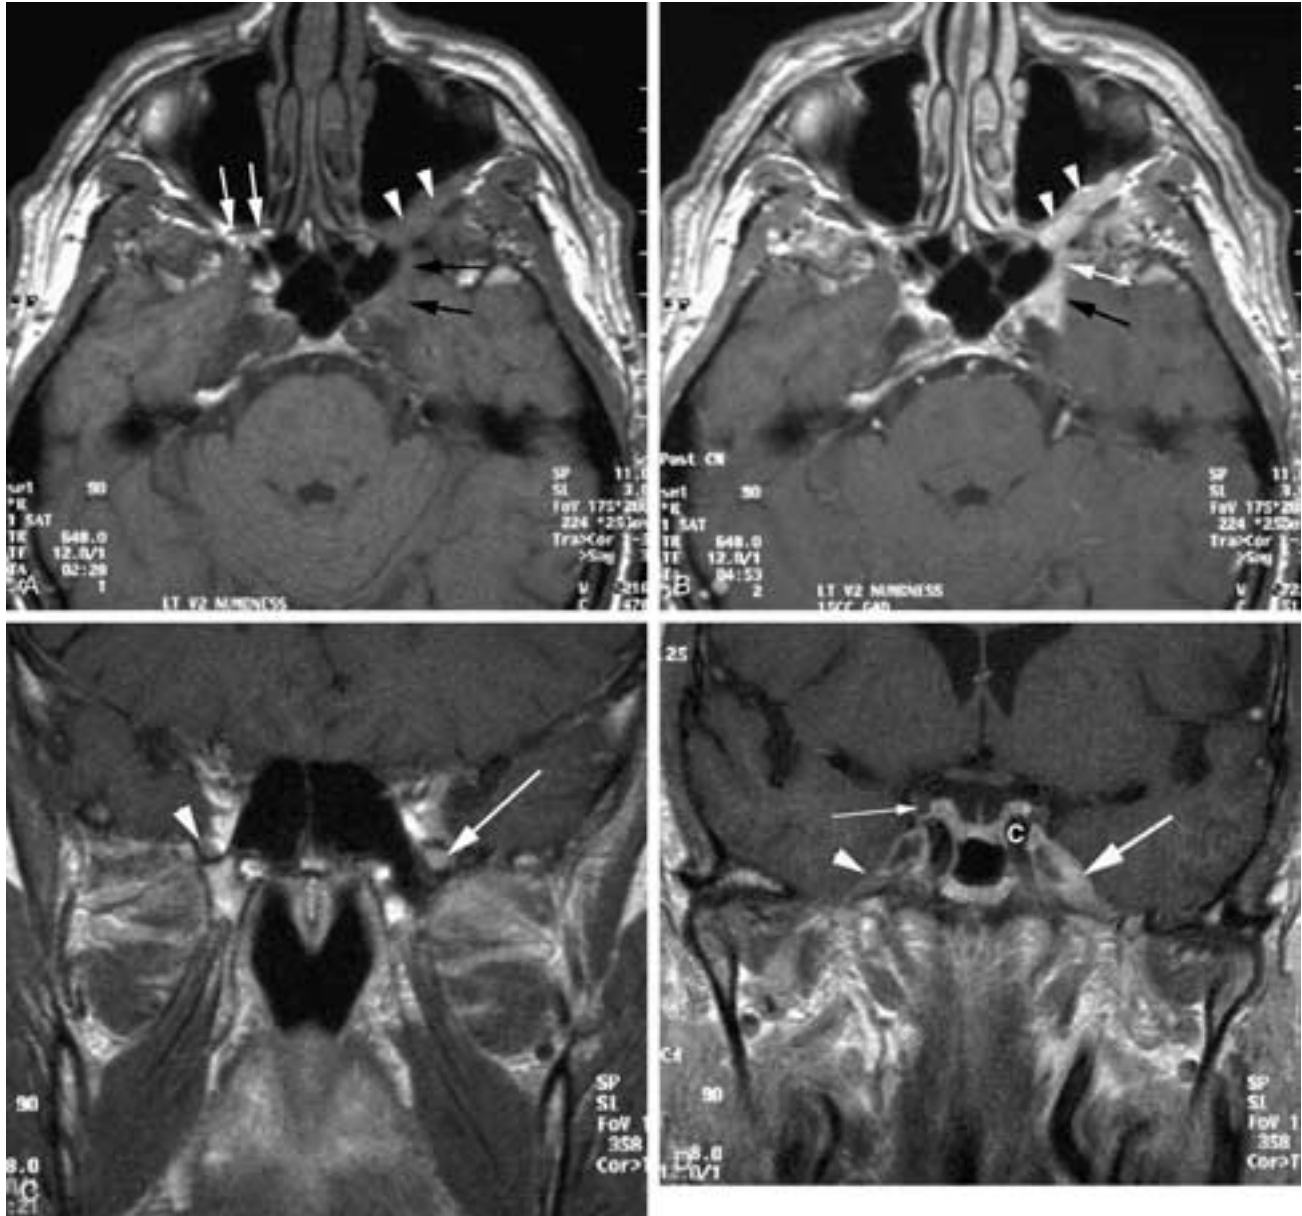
Perineural tumor from the hard palate extending through the pterygopalatine fossa and foramen rotundum into the region of the Gasserian ganglion. A, Axial precontrast T1-weighted image through the pterygopalatine fossa. There is obliteration of the fat as the tumor fills the pterygopalatine fossa (arrowheads). The lesion extends along the foramen rotundum into the anterior cavernous sinus (black arrows). Compare the appearance of the pterygopalatine fossa on the normal side (white arrows). B, Axial postcontrast image. There is enhancement of the tumor in the pterygopalatine fossa (arrowheads). It does not enhance to the signal intensity of fat. Again, the lesion is seen in the foramen rotundum (white arrow) and the anterior cavernous sinus (black arrow). C, Coronal postcontrast T1-weighted image. Note visualization of the actual enlargement of the nerve within the foramen rotundum (arrow). Compare this with the normal nerve on the opposite side (arrowhead) surrounded by a small, enhancing venous plexus. D, Coronal image through the involved region of the Gasserian ganglion. There is intermediate enhancement and thickening of the V (arrow) representing the region of the Gasserian ganglion. Note the normal venous plexus showing slight enhancement around the Gasserian ganglion (arrowhead) on the normal side. Third nerve (small arrow). C, carotid.
